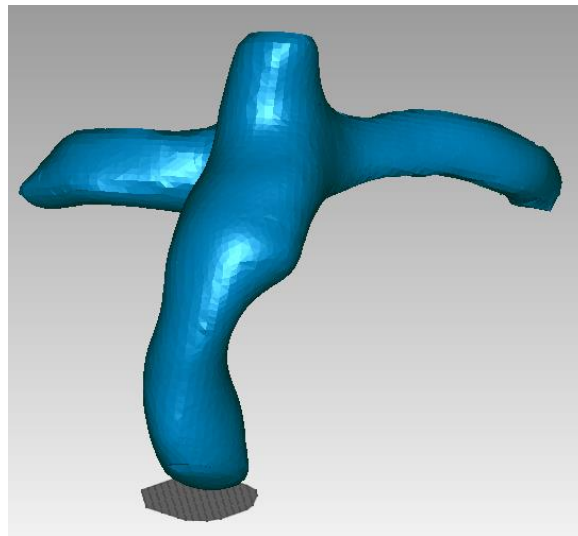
6 The reconstructed 3D patient geometry (blue) and the approximate location and orientation of PC-MRI slice of IVC (gray)
